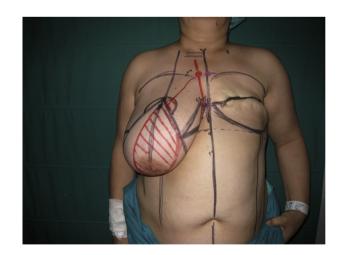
Marks are made with the patient in a standing position and a superomedial-based Wise-pattern-like reduction mammaplasty is performed. Also marked is the Doppler position of the fourth internal mammary artery perforator (IMAP) which will nourish our flap and the second IMAP which will nourish the remaining breast.
